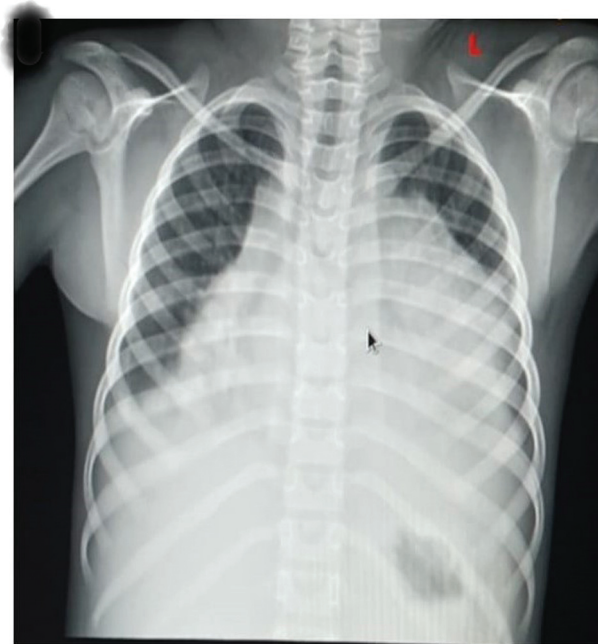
Plain chest X-ray of the patient.
